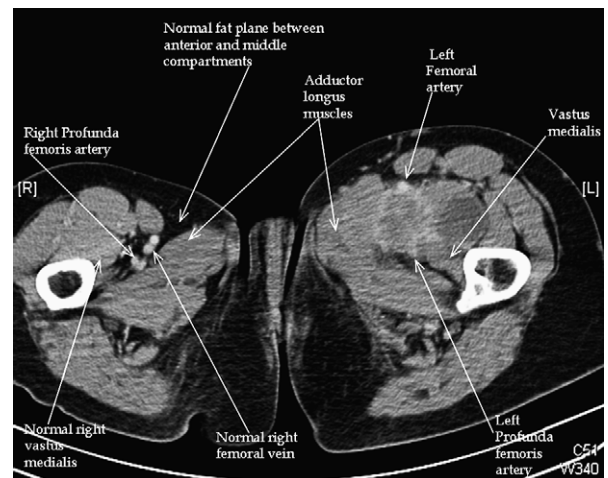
Axial contrast-enhanced CT image shows a heterogeneous, soft-tissue mass filling the fat plane between the anterior and medial compartments of the thigh at the confluence of the superficial and profunda femoris veins. The adductor longus and vastus medialis muscles cannot be delineated separately from this mass. Superficial collaterals noted. The femoral and profunda femoris arteries fill with contrast normally.
